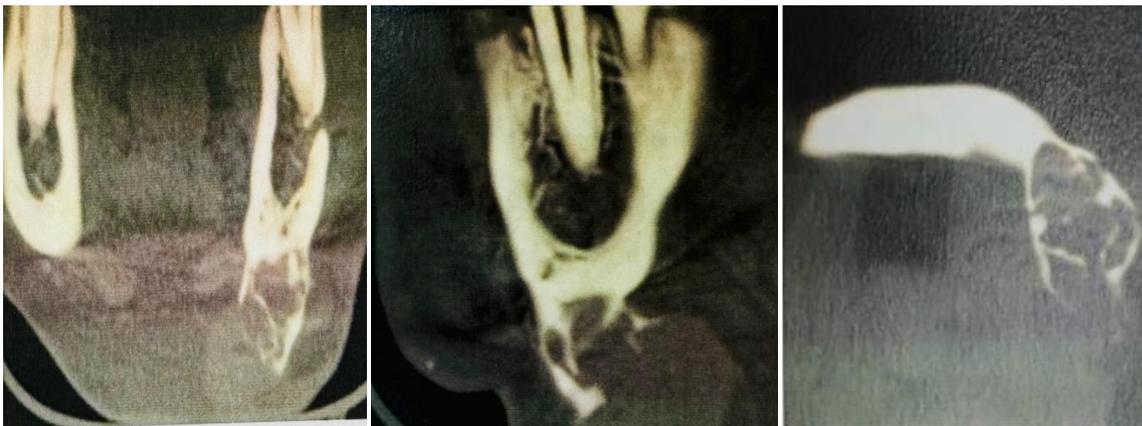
CBCT showing expansile lytic lesion with exophytic component and cortical breach with exuberant soft tissue component
